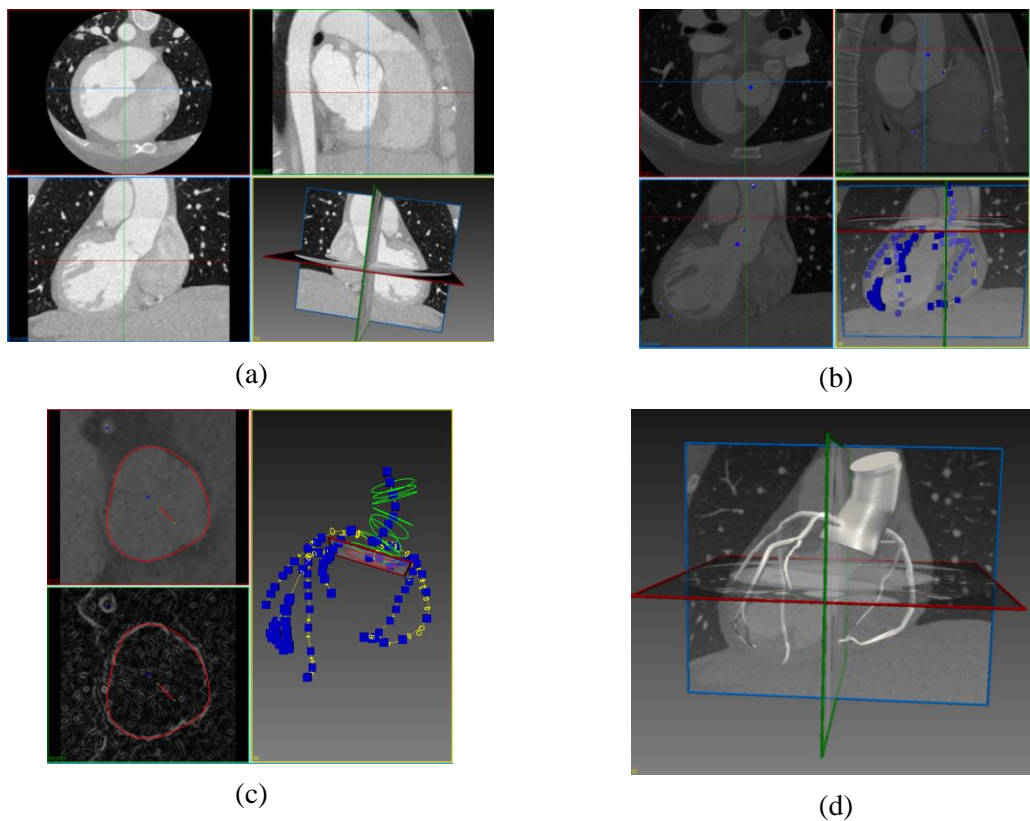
(a) An MRI image file with DICOM format of a healthy 24-year-old person loaded to Simvascular, (b) The paths of the aorta and coronaries are represented by a set of points, which are the approximate center of a vessel's lumen, (c) The segmentation of the aorta and coronary is created, (d) The created solid model represents a volume in space by a set of faces with well-defined boundaries connected to form a closed surface.
